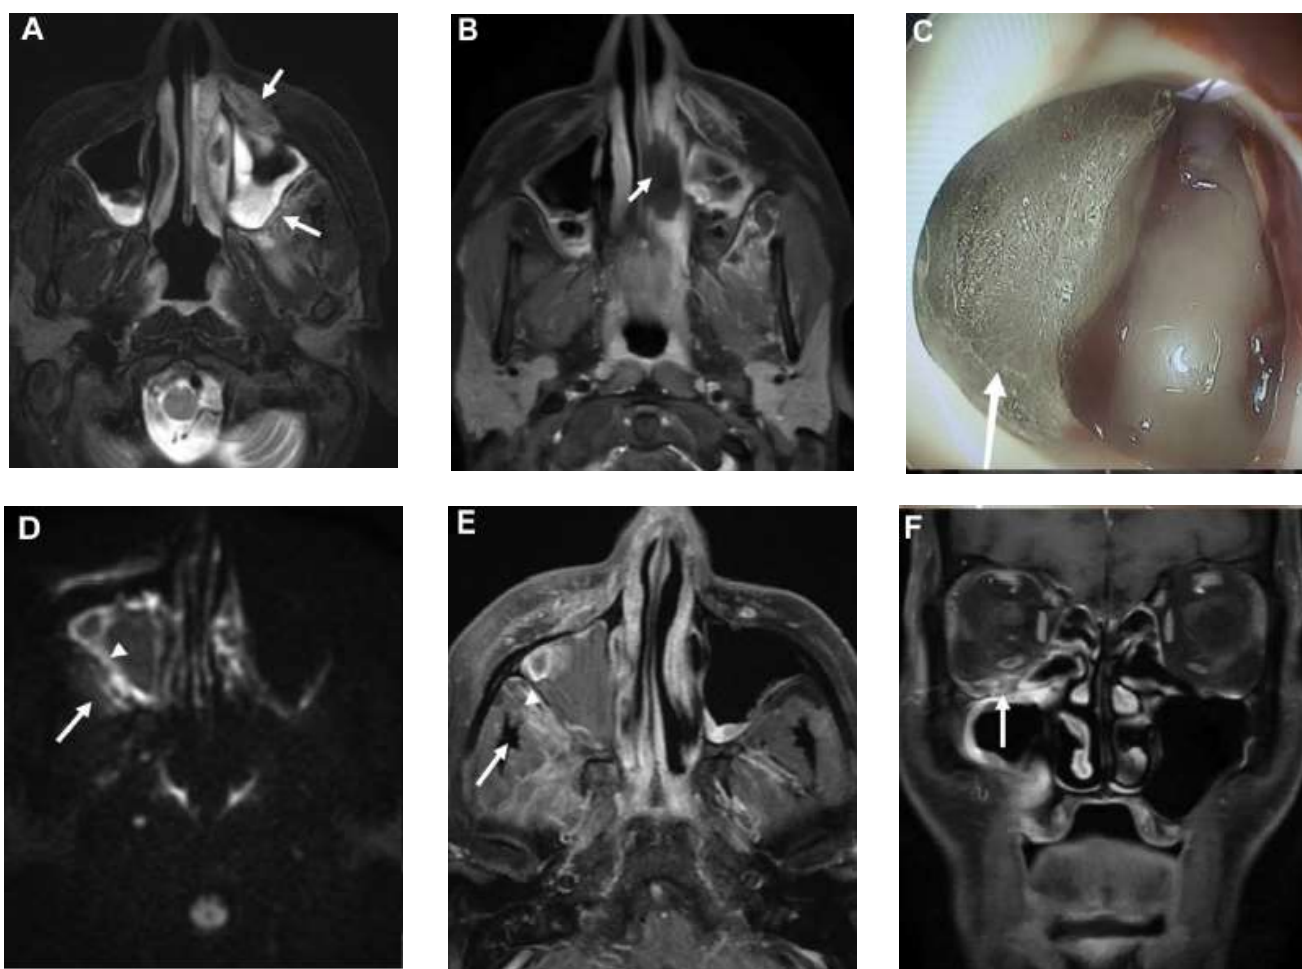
Key imaging features of stage 1 disease. A 65-year-old man, status 21 days' post-coronavirus disease 2019 (COVID-19), presented with facial pain and numbness over 5 days. He was treated and discharged 7 days back from the hospital for moderate COVID-19 pneumonia with a computed tomography (CT) severity score of 15 of 25. The second row is from another patient with similar clinical profile with right-sided paranasal sinus involvement. (A) Axial T2-weighted fat-suppressed image showing early signs of stage 1 rhino-orbital-cerebral mucormycosis. Hyperintensity in the left premaxillary and retroantral region with represents periantral inflammation (arrows). Note the bilateral maxillary sinusitis. (B) Axial T1-weighted (T1W) fat-saturated postcontrast image showing focal area of nonenhancement of the inferior turbinate suggesting necrosis (arrows), the so-called “black turbinate” sign. (C) Nasal endoscopy image depicting fungal colony in the maxillary antrum (arrow). (D) Axial diffusion-weighted image showing bright signal along lateral mucosal wall of right maxillary sinus (arrowhead) and in the retroantral soft tissue (arrow). (E) Axial T1W fat-saturated postcontrast image shows focal lack of enhancement in the lateral wall mucosa of right maxillary sinus (arrowhead) and enhancing retroantral soft tissue (arrow). (F) Coronal T1W fat-saturated postcontrast image shows enhancement along the right infraorbital nerve within the infraorbital foramen suggesting early perineural spread of the disease (arrow). Note the right maxillary sinus mucosal thickening and adjoining orbital fat stranding.
